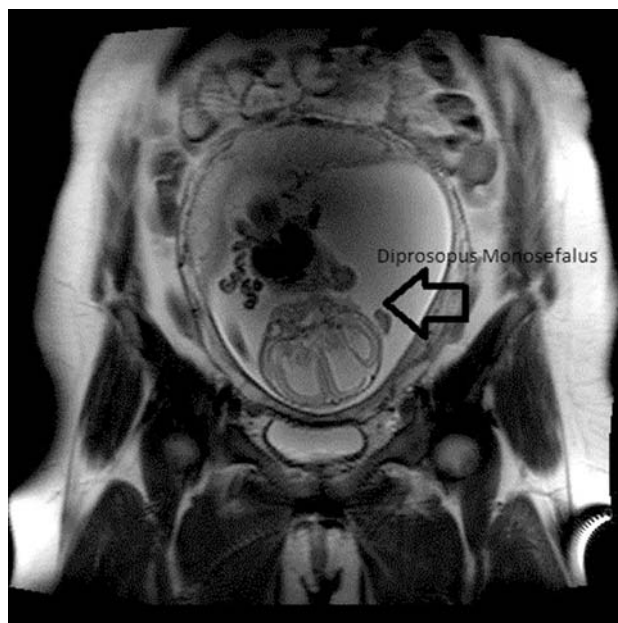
MRI view of double-face, single head.
